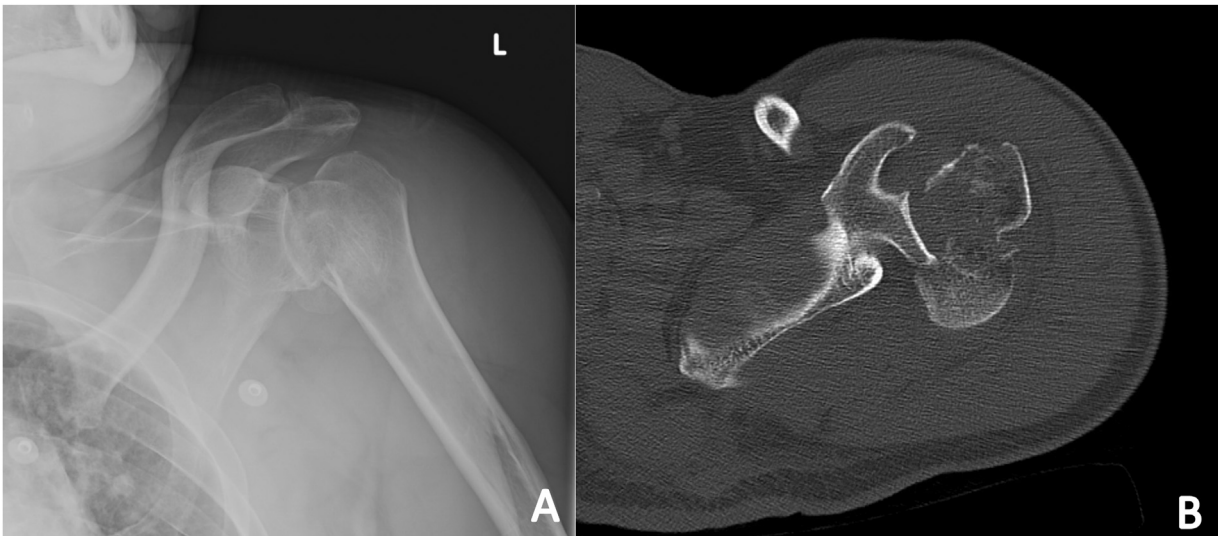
(A) AP radiograph of the left shoulder demonstrating a comminuted proximal humerus fracture. (B) Axial CT image of the left shoulder demonstrating a comminuted posterior fracture-dislocation of the proximal humerus.
